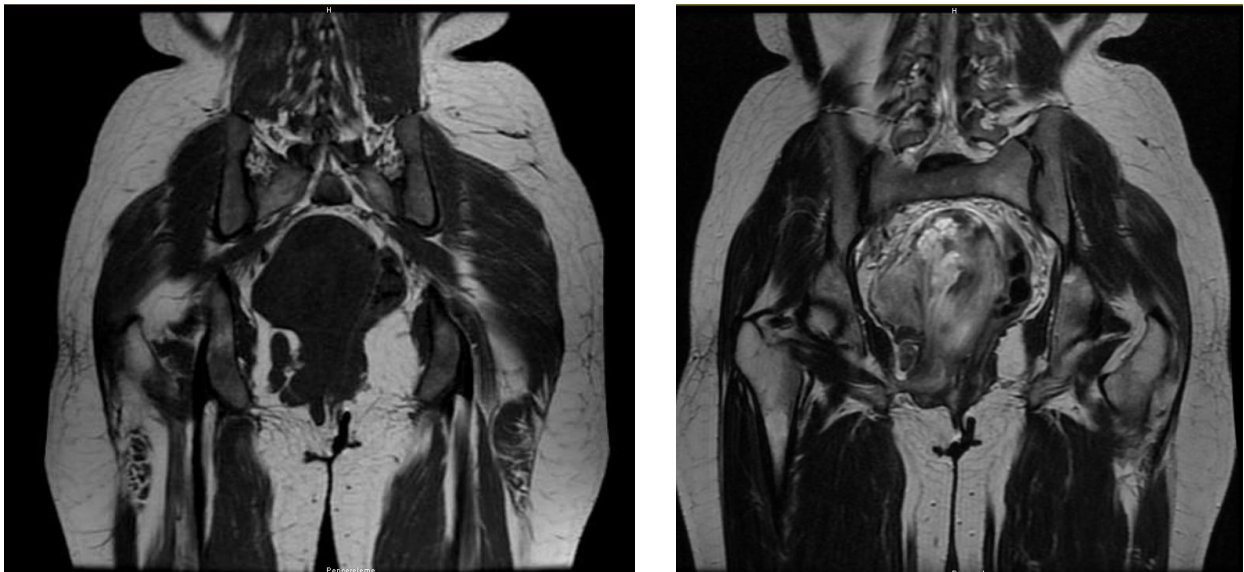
Coronal MRI T1 (Left) and T2 (Right) weighted images showing polypoidal mass arising from right vaginal wall and showing signal intensity similar to muscles with few areas of flow void and necrosis.
